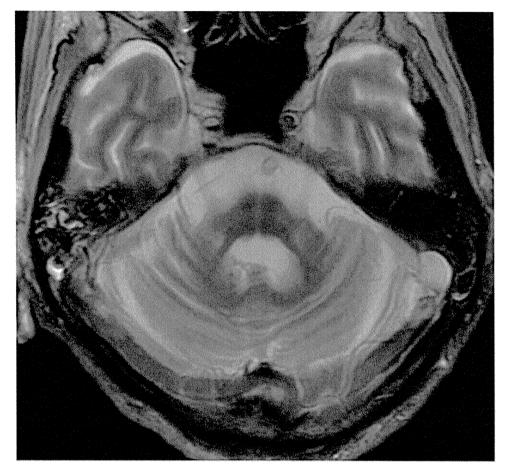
Brain MRI (T2 weighted image) shows severe atrophy of the cerebellum and pons with hot-cross bun sign.
